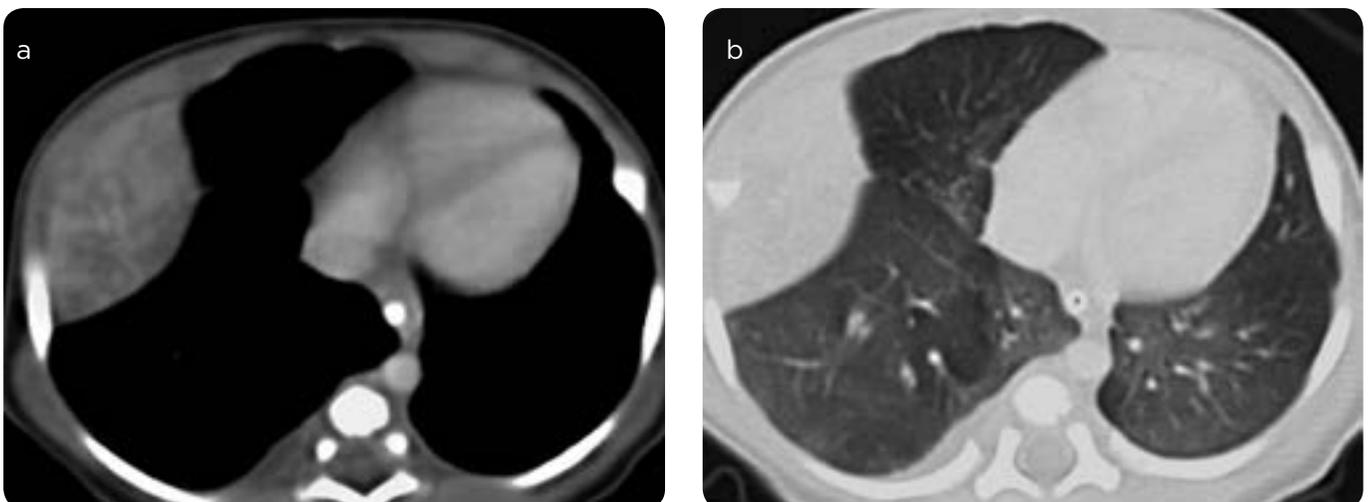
a and b). Type 3 cystic adenomatoid malformation. 2-year-old girl. CT scan of chest, axial, mediastinal window and pulmonary window. Mass in the lower right lobe, broad pleural base, solid, with pointed cystic areas.
